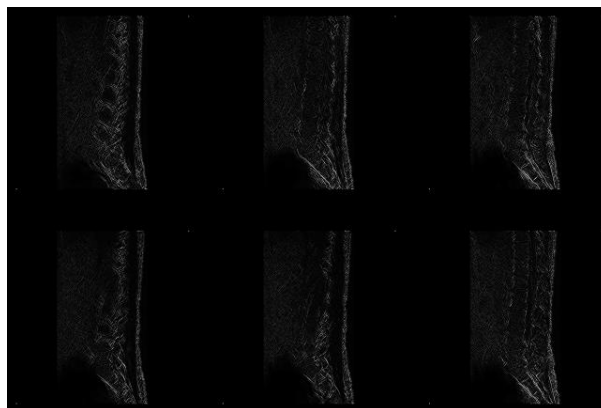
Labeling the filtered CT scan images.
